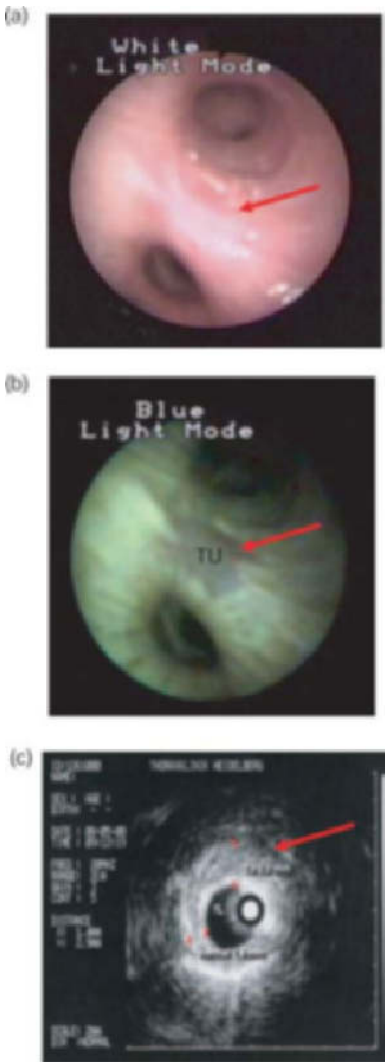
Autofluorescence (AF) and endobronchial ultrasound (EBUS) for detection and local staging of early bronchial carcinoma. By white light bronchoscopy (WLB) a faint discoloration is seen on the middle lobe carina (a). Autofluorescence (D-Light™) system, Storz Co., Tuttlingen, Germany) clearly shows a bluish discoloration at the site of the lesion (b) and by the 20-MHz miniature ultrasound probe (Olympus Co., Tokyo, Japan) the intramural extent of 3 mm and limitation within the confinements of the bronchial wall can be exactly assessed (c).
